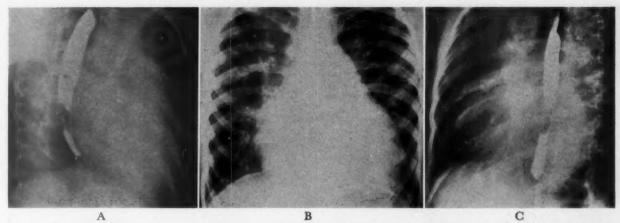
Case 27. Roentgenograms in the right anterior oblique (A), posteroanterior (B) and left anterior oblique (C) positions indicating increased pulmonary vascularity, moderate left ventricular enlargement (B and C), slight to moderate left atrial enlargement (A), and moderate right atrial enlargement (C).
